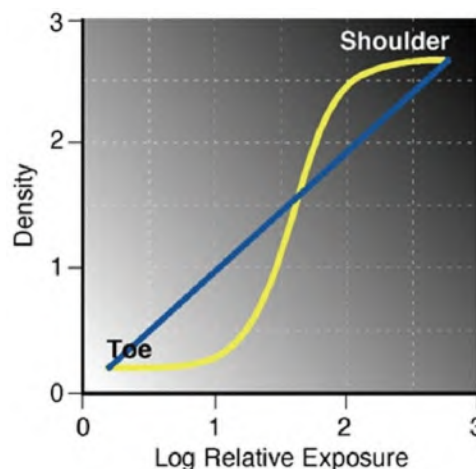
12 Hurter and Driffield curve relating radiograph density to exposure.
